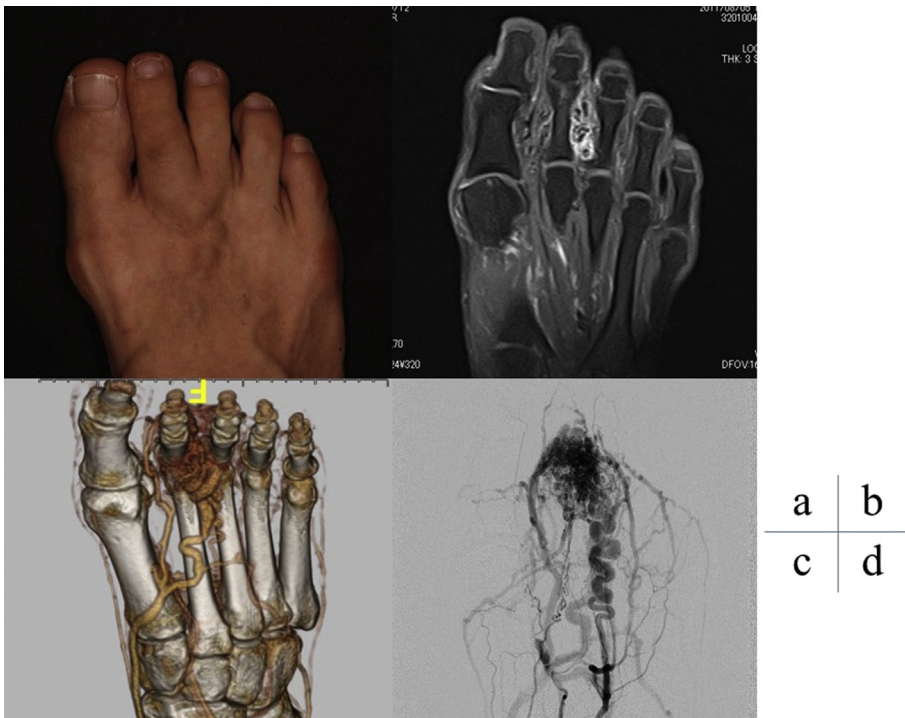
a: The patient presented to our clinic with an arteriovenous malformation in her right foot. b: The T1-weighted image on MRI revealed an arteriovenous malformation in the subcutaneous layer and the bone and tendon tissues were intact. c: CT angiography showed the arteriovenous malformation occurred from the dorsal artery. d: Angiography showed the same result of CT angiography. It affected the digital artery of the second toe.
